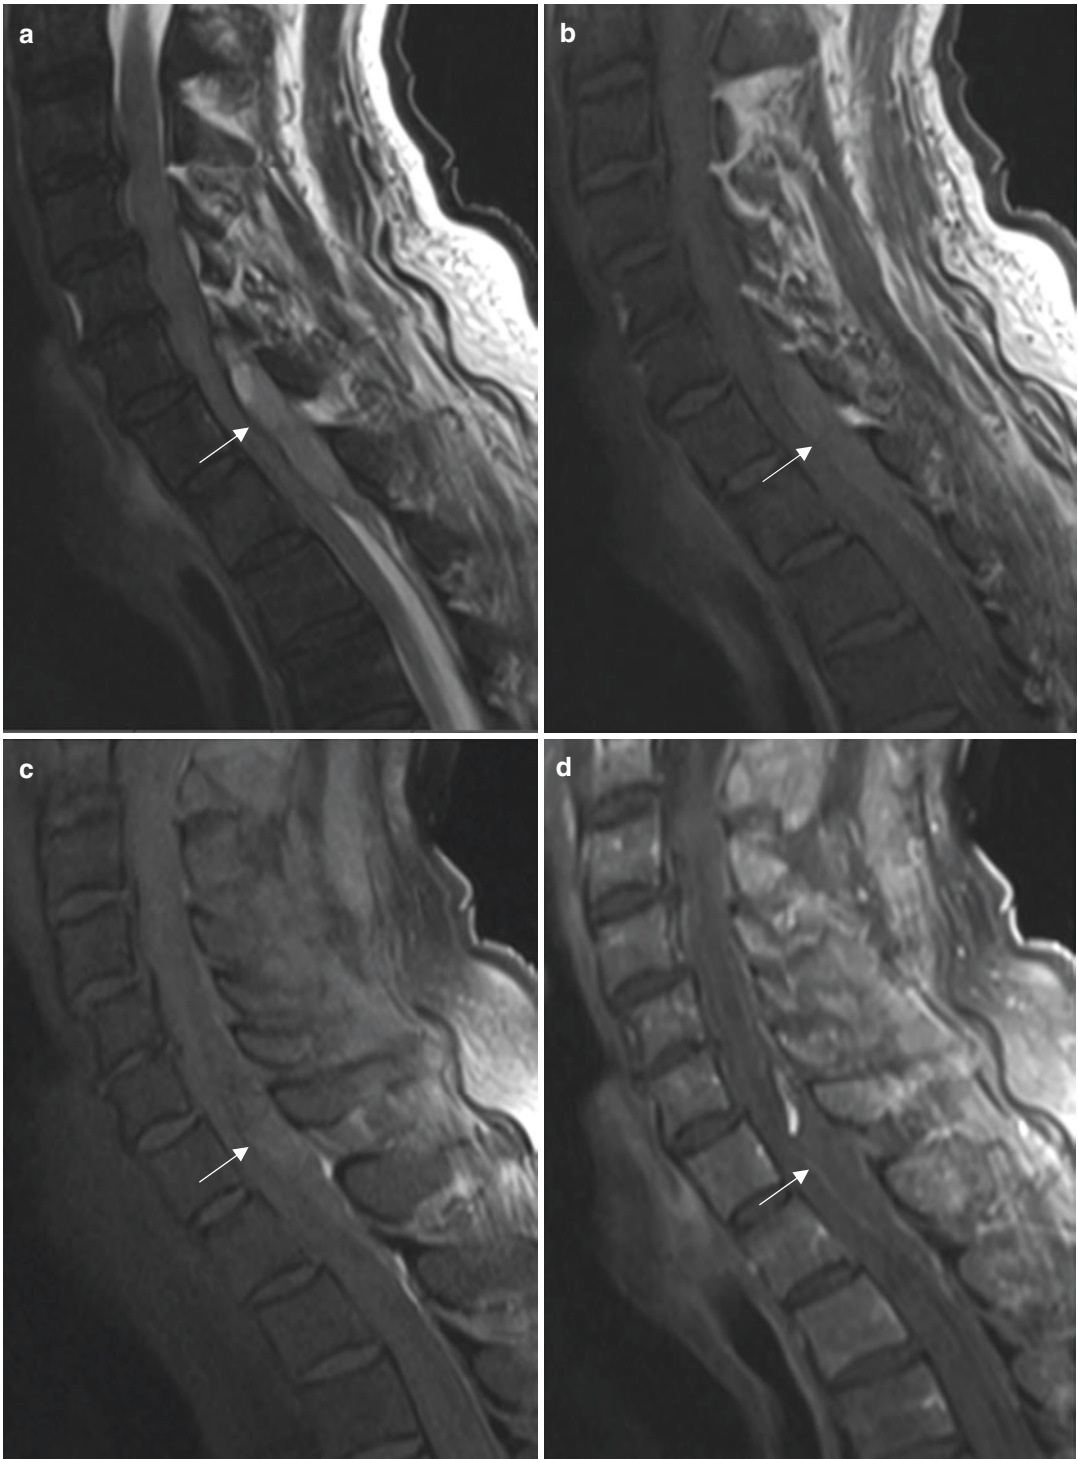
(a) Sagittal T2-, (b) sagittal T1-, and (c) sagittal T2-weighted fat-saturated images of the cervical spine demonstrate an acute dorsal epidural hematoma that is isointense to hypointense to CSF on T2-weighted and mildly hyperintense on T1-weighted images (white
